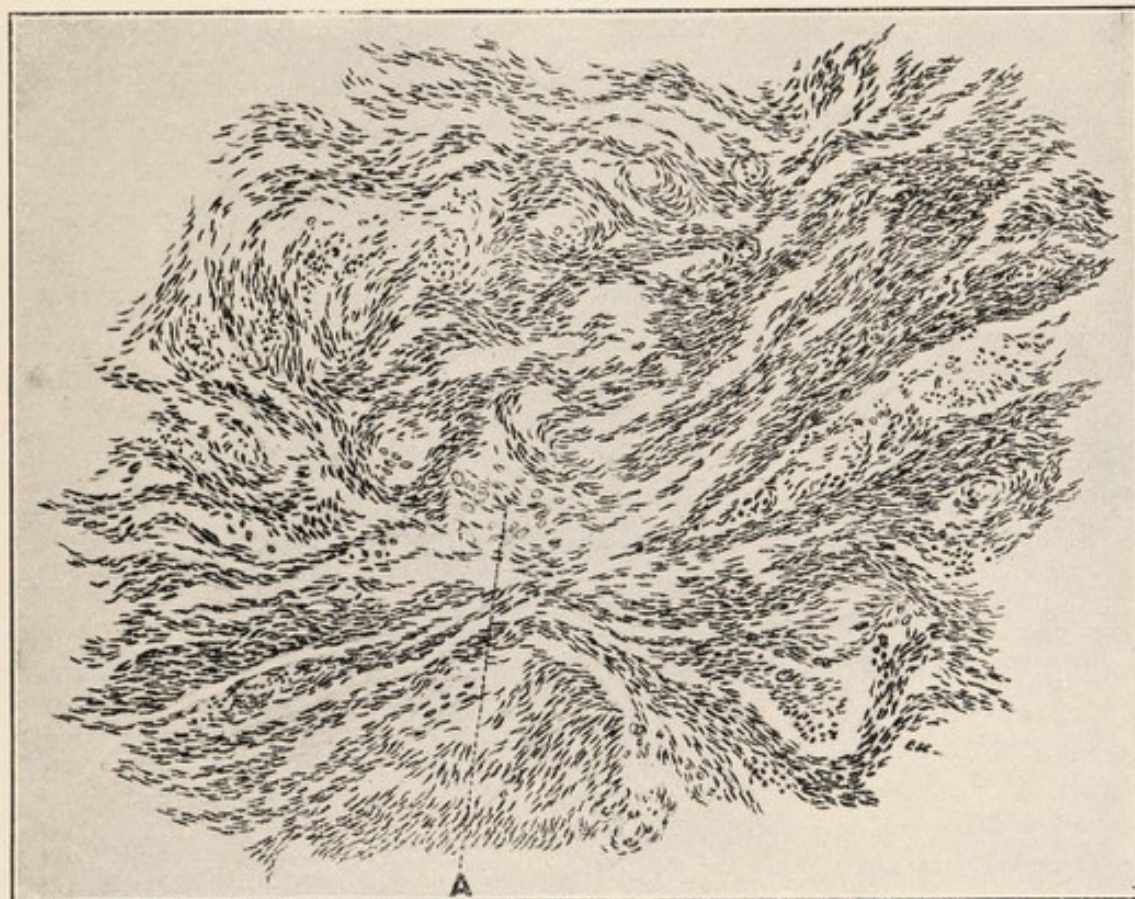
THE UTERUS WAS REMOVED THREE MONTHS AFTER THE APPLICATION OF ABOUT 175 PER CENT E. S. D. OF RADIUM AND X-RAYS. Note the connective tissue formation and practically total absence of malignant cells.
